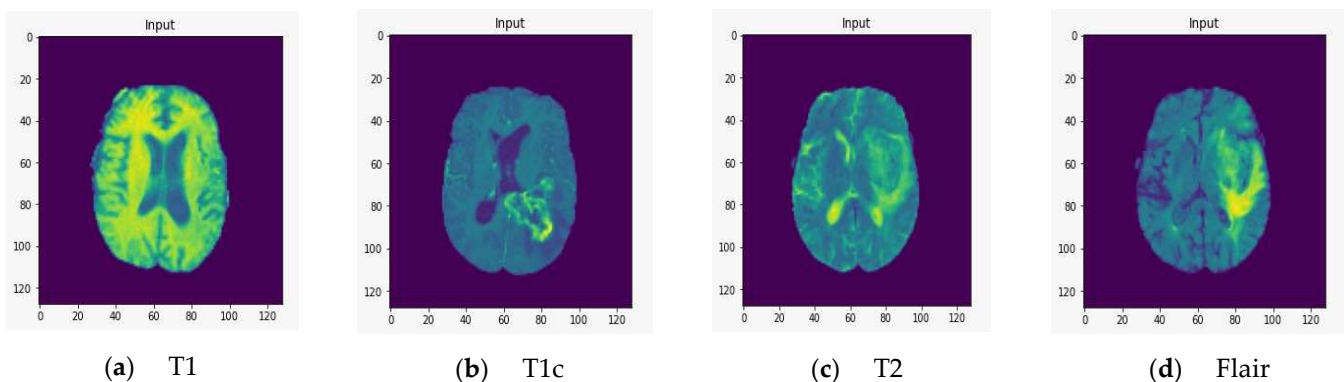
T1, T1c, T2, and FLAIR rendered at a resolution of $128 \times 128 \times 128$.
